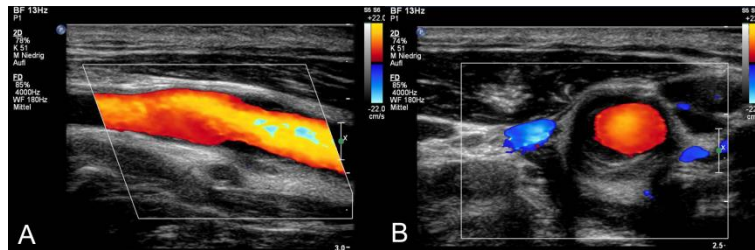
A 52-year old male patient presented with pain and tenderness on palpation during the last 3 days located at the region of the left carotid bifurcation. He had no cardiovascular risk factors and did not remember any previous trauma of the neck. Based on the clinical presentation and the results on standard ultrasound imaging the diagnosis of transient perivascular inflammation of the carotid artery (TIPIC) syndrome was made. B-mode ultrasound imaging using a 5-17MHz linear probe revealed a perivascular hypoechoic thickening at the bulb of the internal carotid artery with outward extension of the vessel in the longitudinal (A) and cross-sectional view (B). The lesion has an onionskin like appearance on B-mode ultrasound. No relevant stenosis of the carotid artery on colour-Doppler ultrasound was found.
